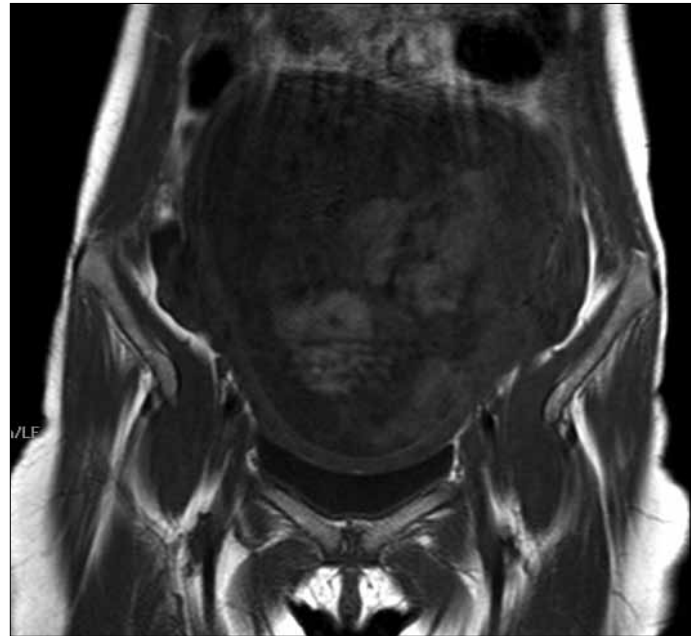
On coronal T1 weighted image blood products within the amniotic fluid appear as hyperintense structures against the dark background of amniotic fluid. Engulfed blood within the intestines of the fetus appears mildly hyperintense too. This finding corresponds to the “echogenic bowel” sign in ultrasound
